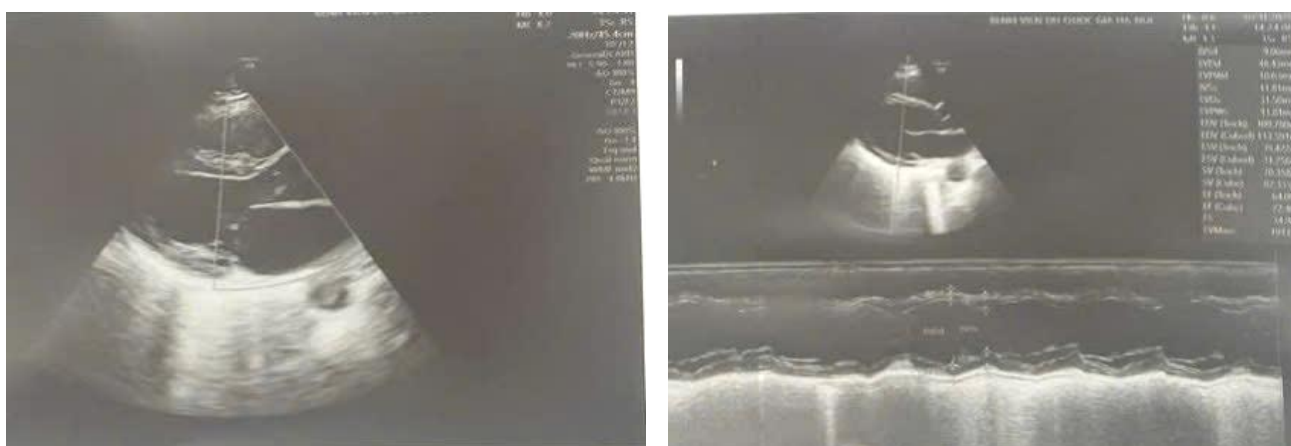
Echocardiography: Occasional ventricular premature contractions were noted during the examination. There was evidence of mild mitral and aortic regurgitation. Left ventricular size and systolic function (Ejection Fraction: 64%) were within normal limits.
